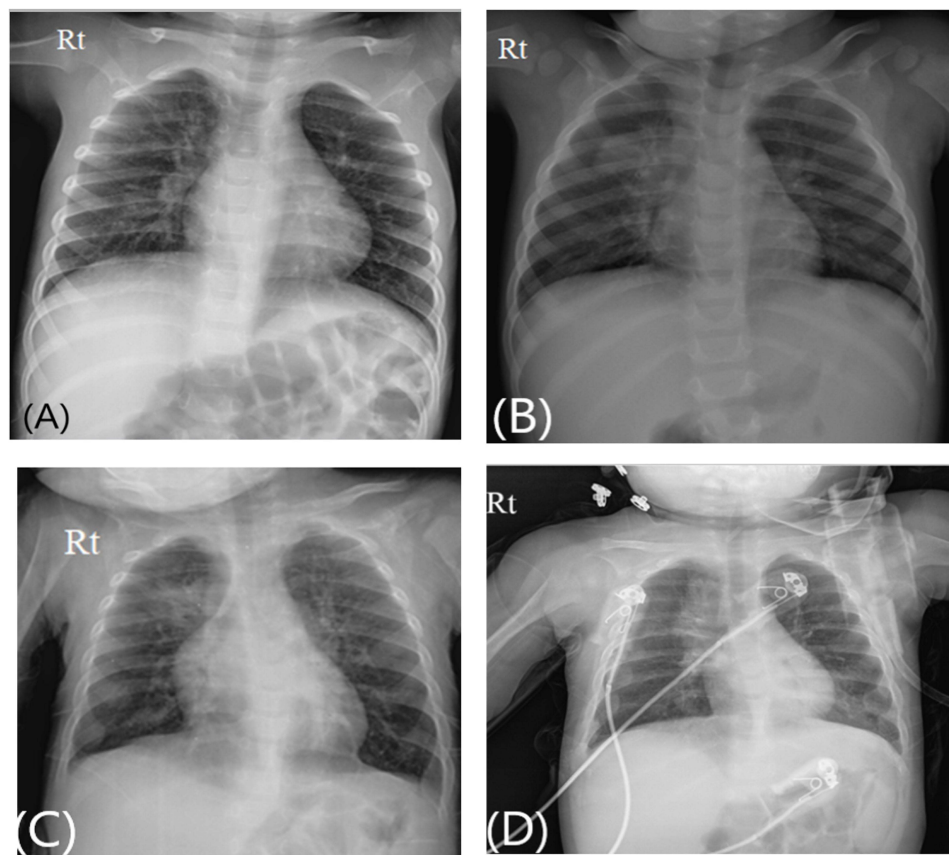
Radiological presentation of selected pediatric measles cases. (A) A 22-month-old female patient; Chest X-ray: Bronchopneumonia. Thickened and blurry pulmonary markings in both lungs with reticular shadows, more evident on the right side. Small patches of blurry shadows in the right lower zone and hilum. (B) A 2-year-old male patient; Chest X-ray: Pneumonia. Area of consolidation in the right upper lung. (C) A 7-month-old female patient; Chest X-ray: Pneumonia. Thickened and blurry pulmonary markings in both lung fields, with patchy area of consolidation in the right upper lung. (D) A 7-month-old male patient (death), Chest X-ray: right upper zone consolidation with air-bronchogram, and right hilar lymphadenopathy.
